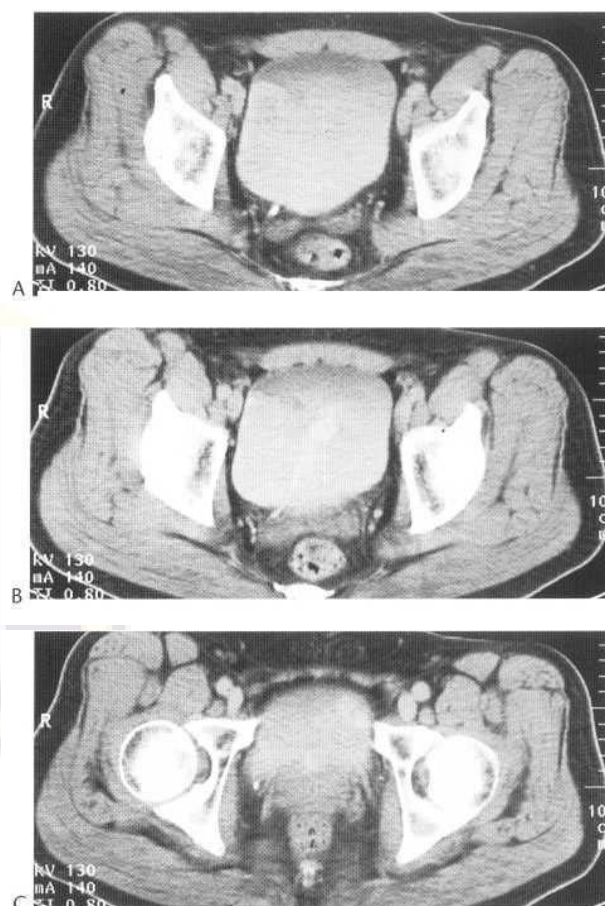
CT of the pelvis showing the distal ureters just above the vesicoureteric junctions lying anterior to the seminal vesicles (A). The right ureter happens to contain a bolus of contrast at the time of the scan. (B) shows the ureters at the vesicoureteric junctions with a jet of opacified urine projecting from the right ureter into the bladder. Further inferiorly the prostate is seen just projecting into the bladder base (C).
